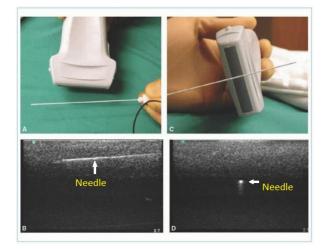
A is In-Plane technique of needle insertion and B is the ultrasound picture of that technique.
